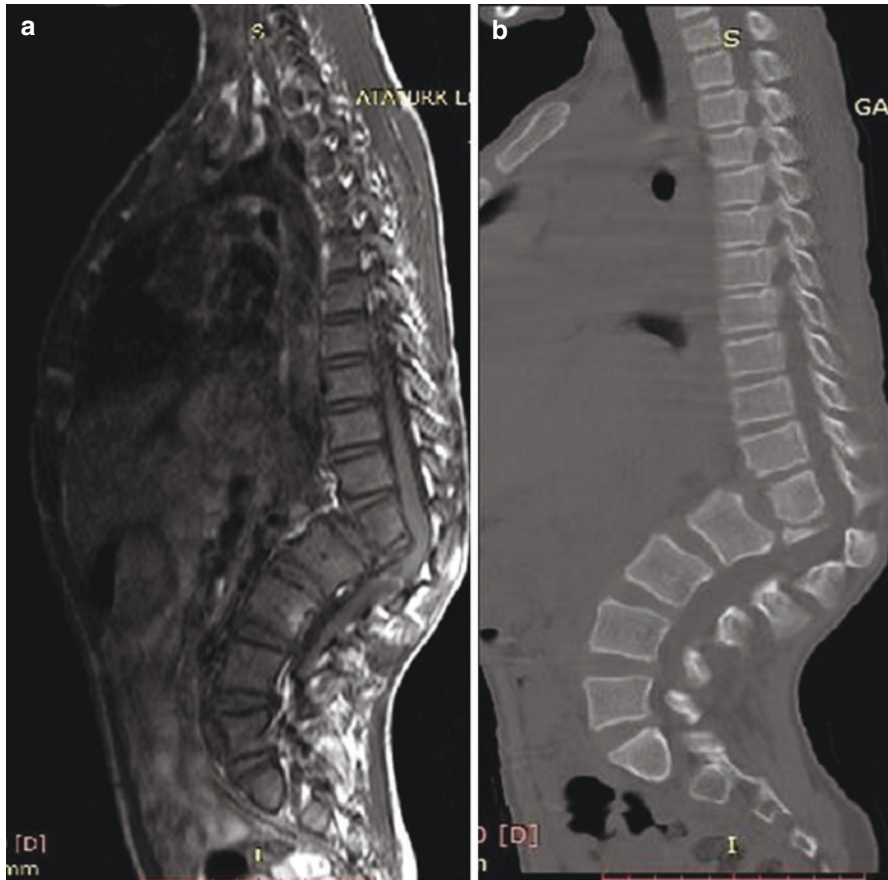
(a and b) Show CT and MRI imaging revealing a L1 vertebral body collapse and kyphotic deformity. It can be classified as Kyphosis Classification (Rajasekaran) type IIIB (Appendix P) [Courtesy of Prof. Alpaslan Şenköylü]
